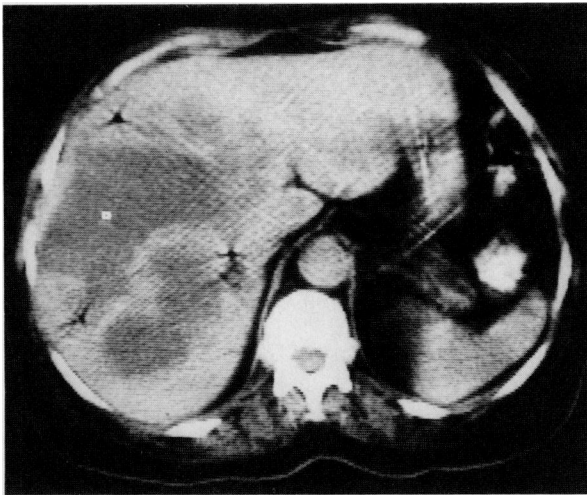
CT of abdomen demonstrating a large multi-locular abscess in a 62-year-old woman with a type 2 hepatic perforation of the gallbladder
